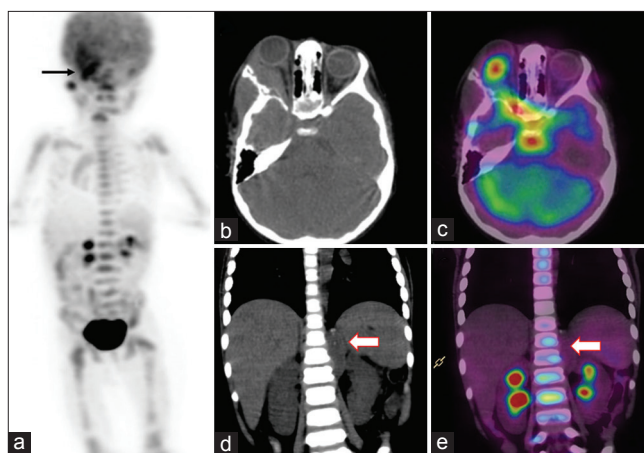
Diffuse large B-cell lymphoma of orbit: Fluorodeoxyglucose positron emission tomography/computed tomography images of a case of orbital diffuse large B-cell lymphoma. Maximum intensity projection image (a) shows no abnormal tracer distribution in rest of the body. (Note: uptake in thorax corresponds to calcified mediastinal nodes and not of lymphoma.) Axial images (b and c) show the hypermetabolic mass involving left orbit and adjacent left ethmoid sinus. A patient received radiotherapy and chemotherapy and positron emission tomography/computed tomography scan done at the end of treatment shows complete metabolic response (e) with residual nonviable tissue (d)
